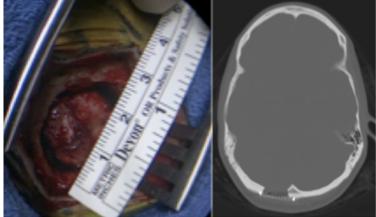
intraoperative image showing the incison and craniotomy diminute dimensions and postoperative bone window CT scan demonstrating the small bone removal.
